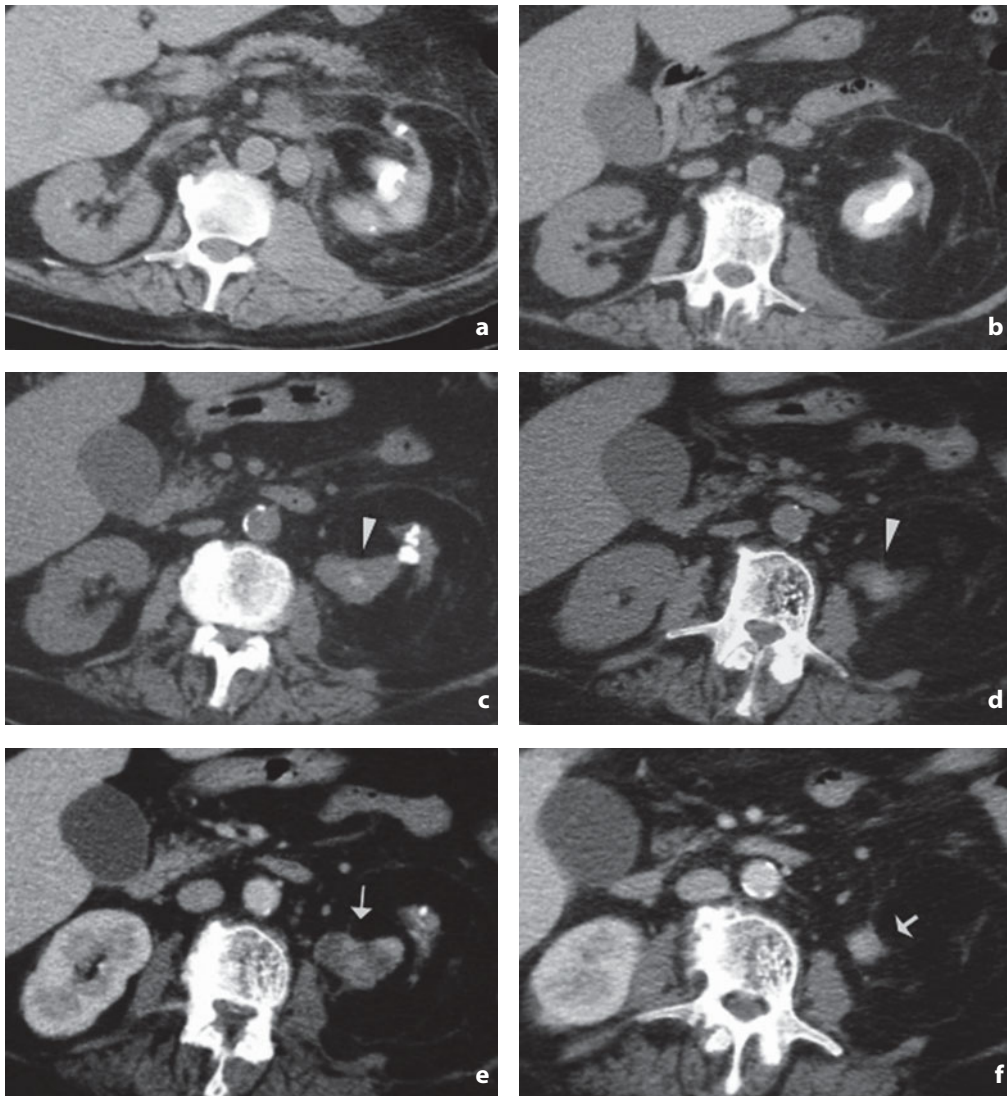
Computed tomography. Transitional cell carcinoma in kidney with staghorn calculus. In the baseline scans (a-d) the left renal pelvis is occupied by stones and the ureteropelvic junction, with the proximal segment of the ureter, appears distorted and with solid attenuation (*arrowhead*). After contrast medium injection, the venous phase images show the heterogeneous enhancing pelvic mass (e) and solid tissue occupying the proximal segment (f) of the ureteric lumen (*arrows*)
